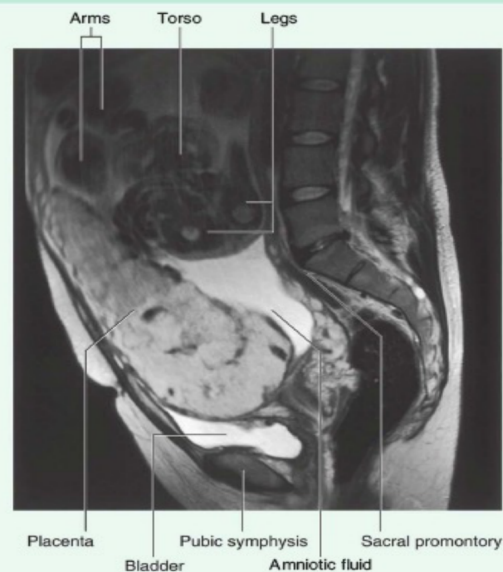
Sagittal T2-weighted magnetic resonance image of the lower abdomen and pelvis of a pregnant woman.
